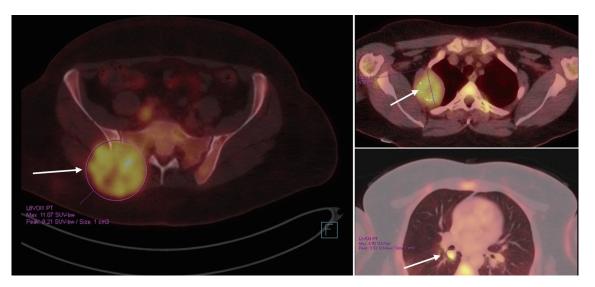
PET/CT scan showing widespread metastatic disease (arrows) (September 10, 2020). Beta-hCG level was within normal levels. Beta-hCG: beta human chorionic gonadotropin; CT: computed tomography; PET: positron emission tomography.
